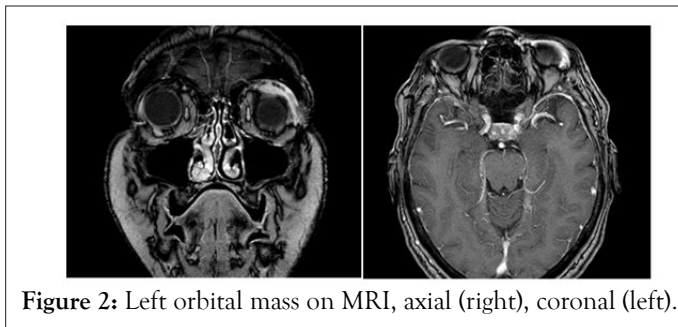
Left orbital mass on MRI, axial (right), coronal (left).
